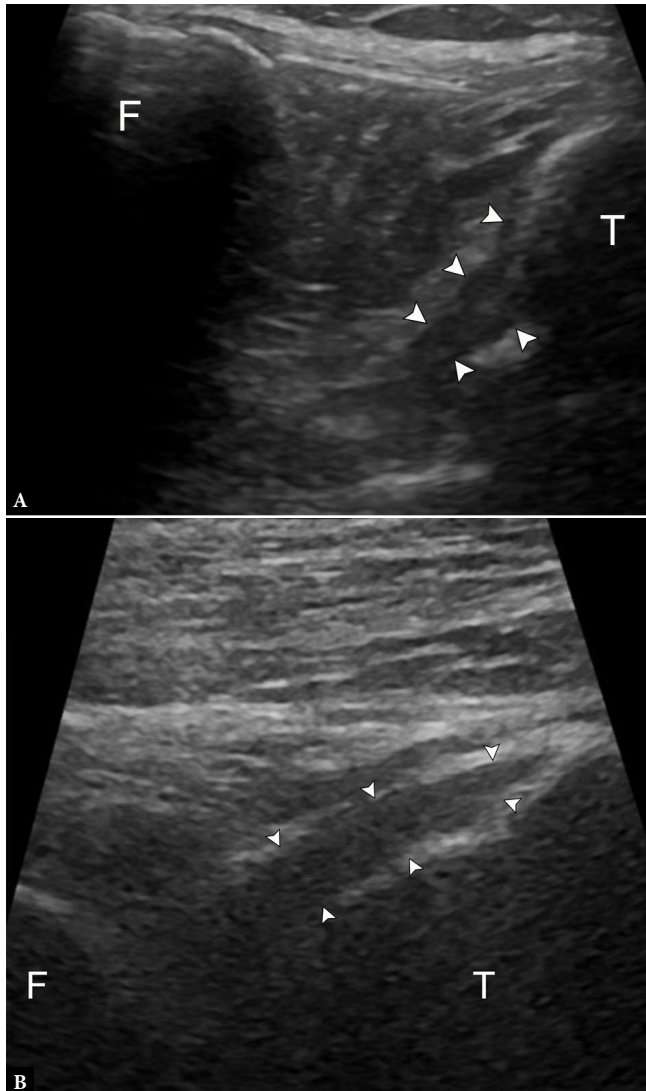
53-year-old female with knee pain, unable to undergo MRI. A. Longitudinal grayscale US image slightly oblique to the patellar tendon with knee flexion demonstrates no tear at the tibial insertion of the anterior cruciate ligament (ACL) (arrowheads). T – tibia, F – femur. B. Longitudinal grayscale US image at the central posterior tibial plateau with knee flexion demonstrates no tear at the tibial insertion of the posterior cruciate ligament (PCL) (arrowheads). The femoral origin of either ligament is not visible
